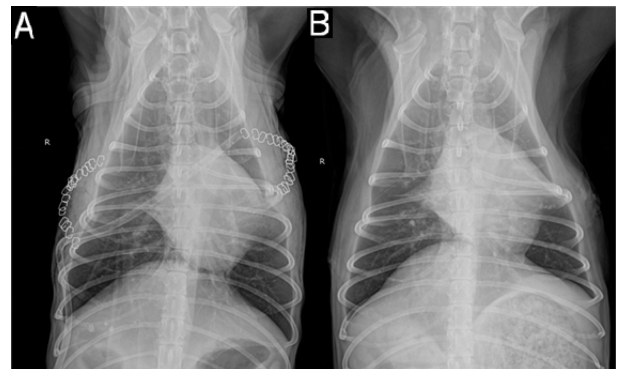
Survey thoracic radiographs show no signs of pneumothorax on the day of surgery (A) and on the 12 days after surgery (B).
